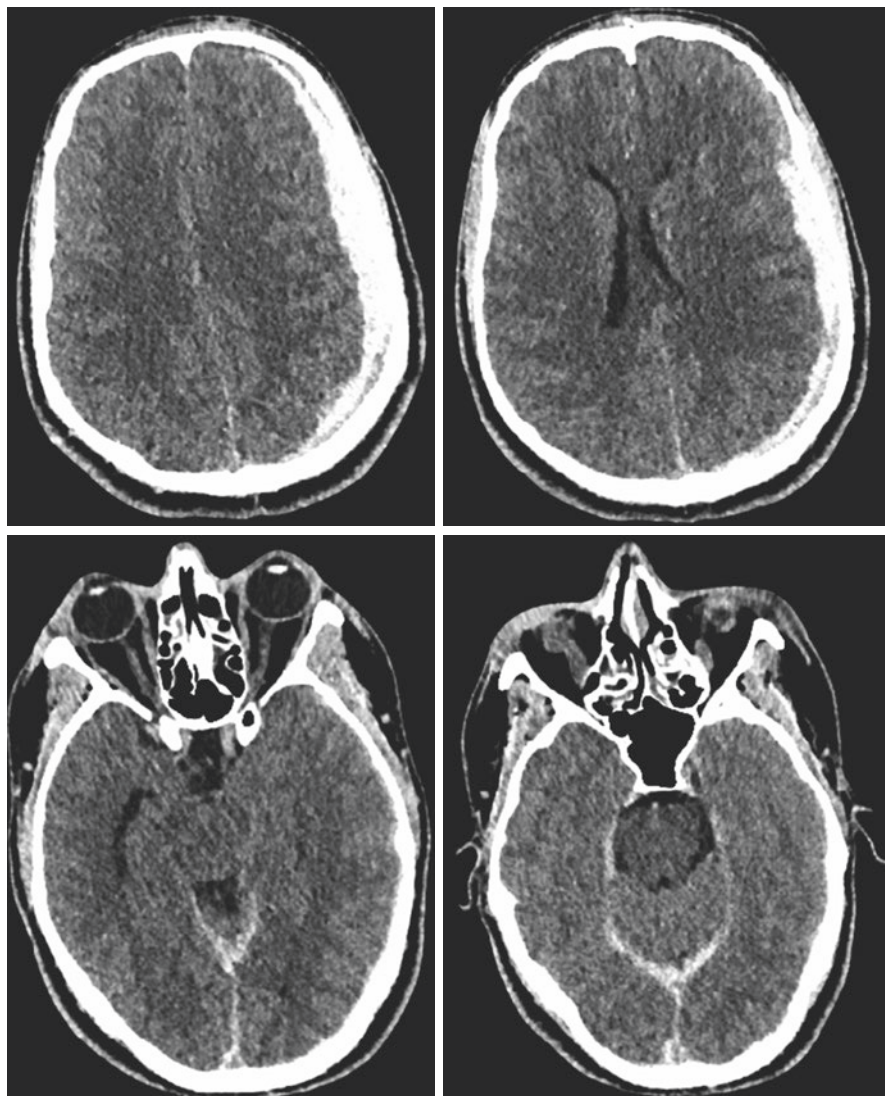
CT head without contrast reveals a thin, left-sided acute subdural hematoma and left temporal intraparenchymal contusions, as well as contusions in both inferior frontal lobes; traumatic subarachnoid hemorrhage; and a small amount of intraventricular hemorrhage. There is left to right midline shift measuring 4 mm. There is no hydrocephalus
